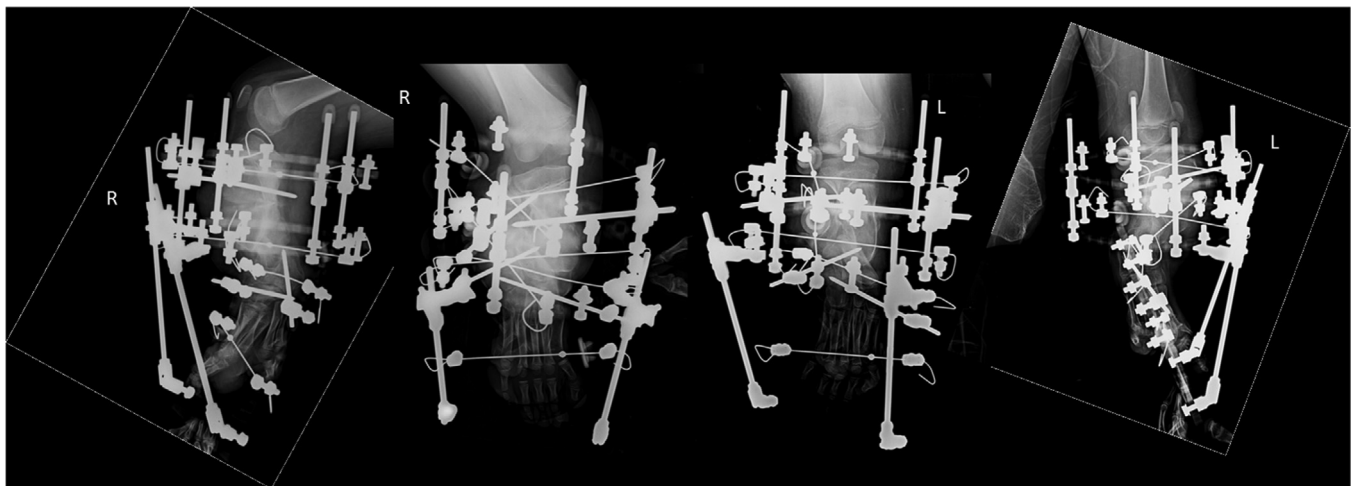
At 6 years of age, early postoperative radiographs of the patient display bilateral tibial lengthening and deformity correction with a monofocal tibiofibular osteotomy using a circular external fixator.
